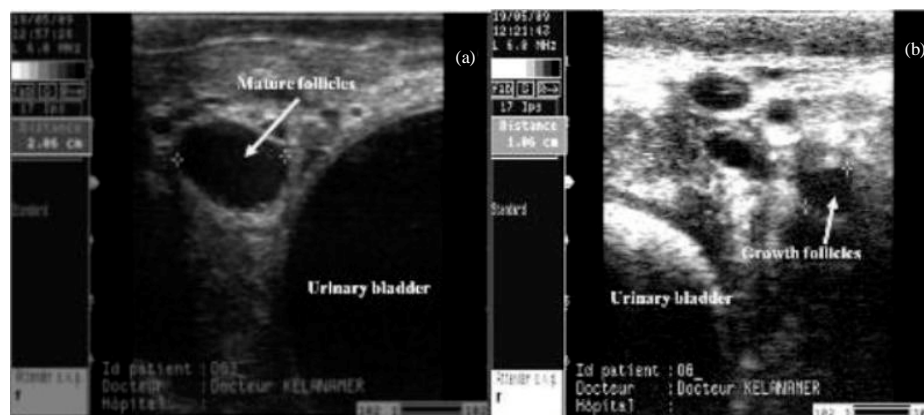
Ultrasonography of follicles in female camel; a) mature follicular and b) growth follicular
